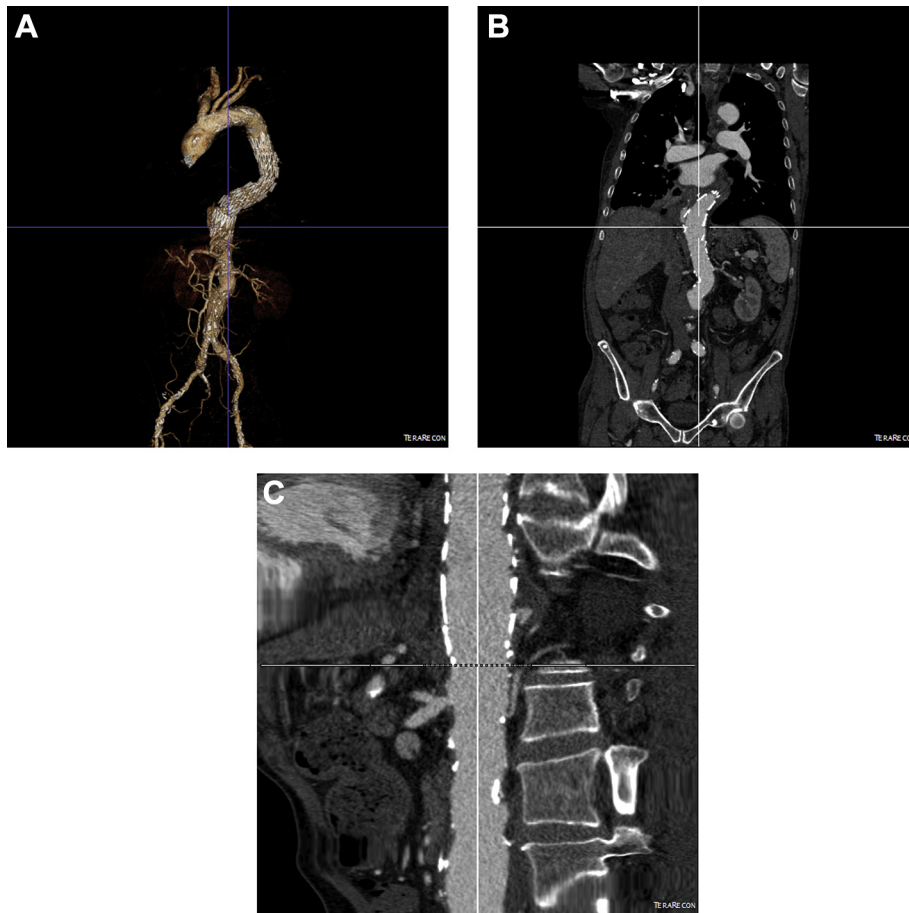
A distal type I endoleak is shown after the first procedure on the computed tomography three dimensional volume rendering (A) and sagittal (B) multiplanar reconstructions. The stretched curved planar reconstruction (C) confirms that the distal end of the thoracic endograft is positioned just above the origin of the celiac trunk.
